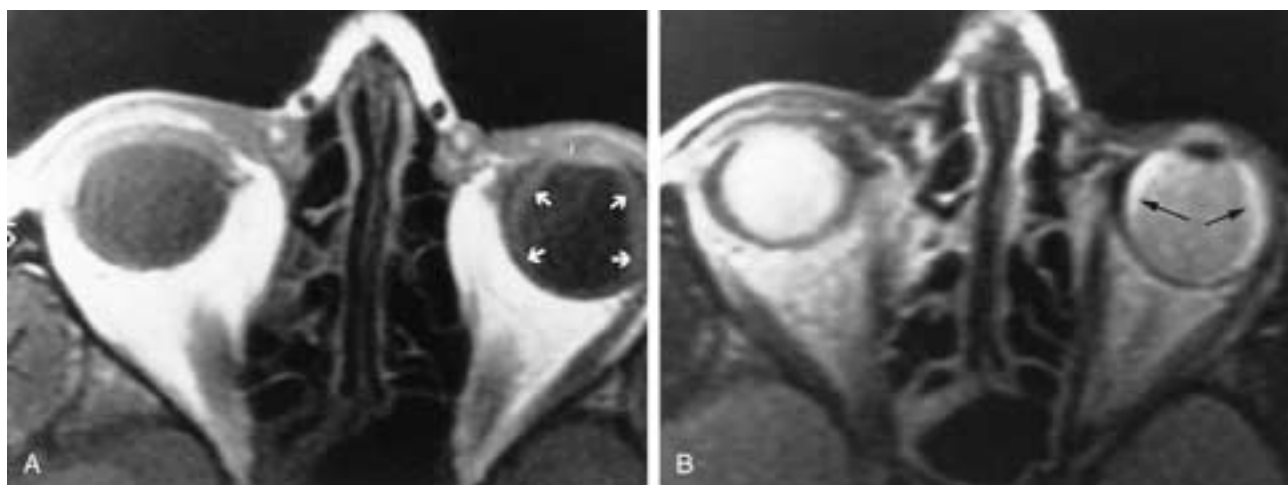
Choroidal detachment. A, Axial PW and B, T2-weighted MR images. Scans show the choroidal effusion of the left eye as a ring-shaped area of increased signal intensity (arrows).
